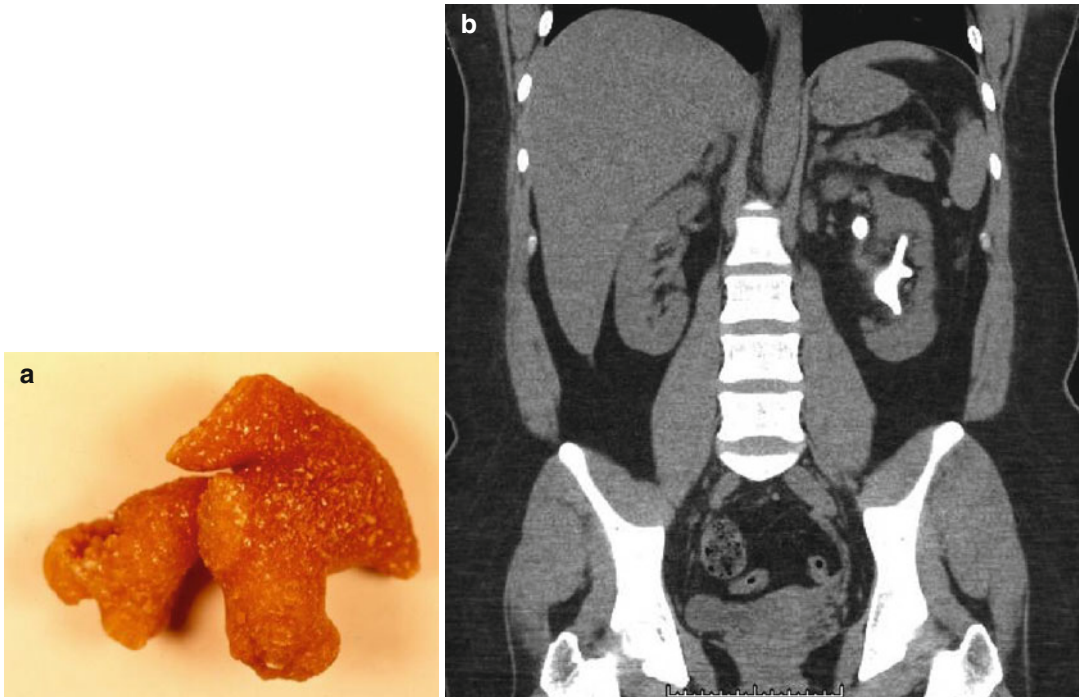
Large cystine stone (a) and coronal CT scan image (b) demonstrating a left staghorn calculus and a smaller left upper pole stone
